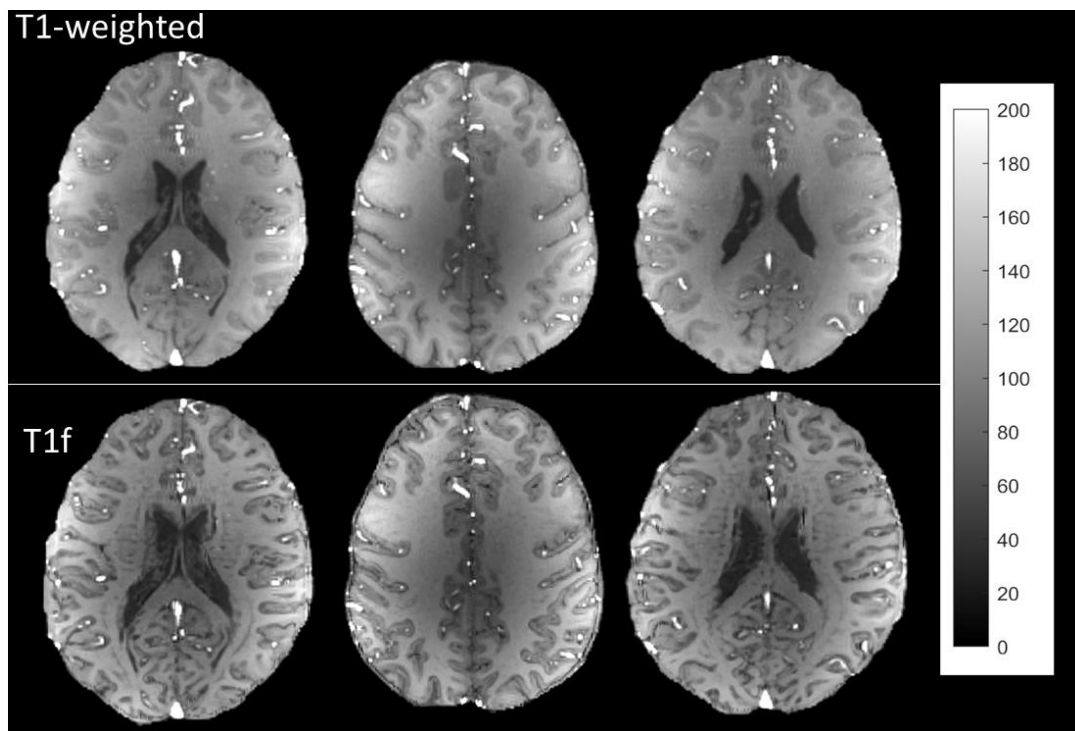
T1-weighted image obtained from GEPCI imaging (top row), and the corresponding T1f image obtained by 2 frequency mask multiplications (bottom row). GM/WM T1 contrast is enhanced in the T1f images compared to the T1-weighted images. One can also see some venous information on the T1-weighted image.
